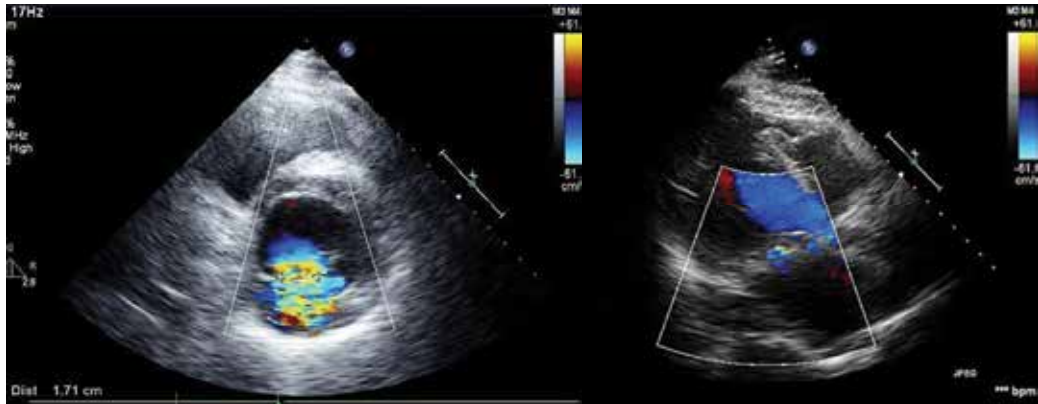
Patient Ch. Preoperative echocardiography (left, two-chambered position at the mitral valve level) and postoperative view (right, four-chambered position).
